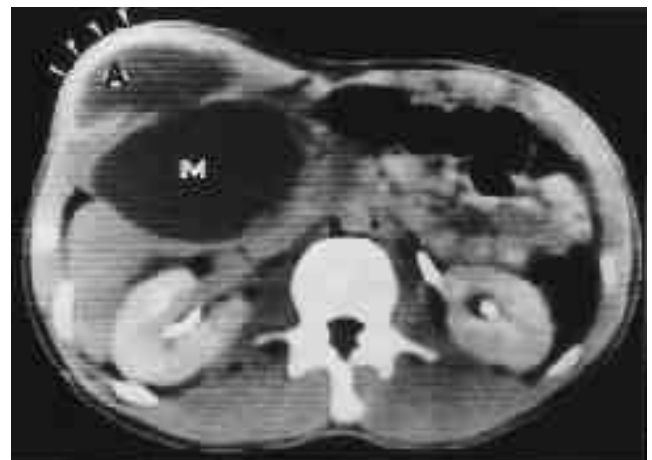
A 19-year-old male patient with tuberculous abscess in the right subphrenic space. Contrast enhanced CT shows a cystic mass (M) in the perihepatic space with rupture into the adjacent abdominal wall (A) .
